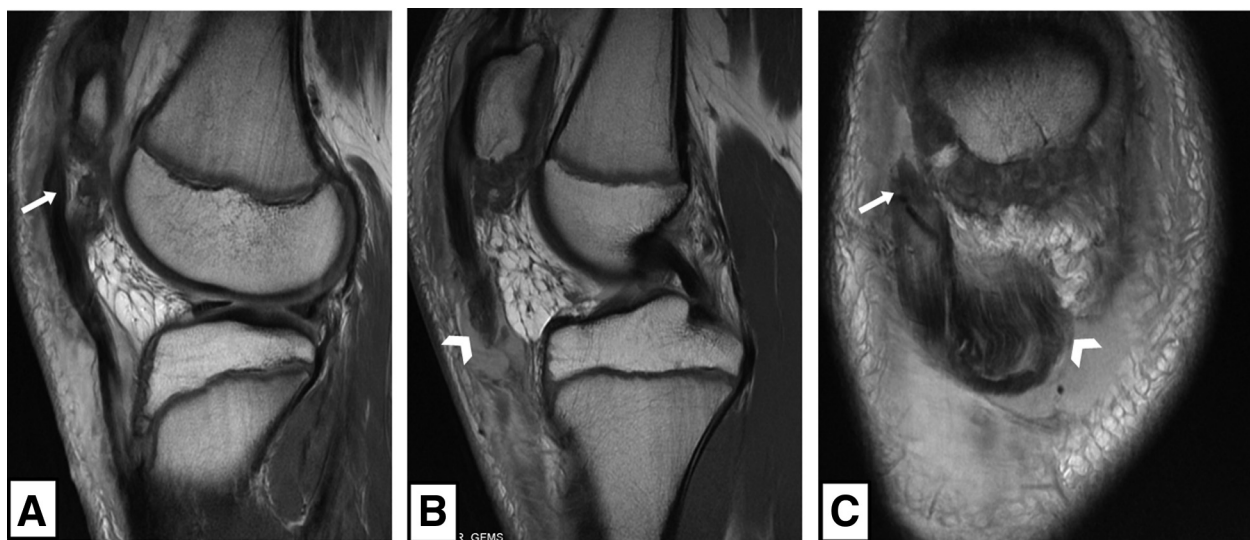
Case 4 preoperative magnetic resonance imaging (MRI) (right knee). Preoperative sagittal proton density MRI sequences from case 4 show proximal avulsion of the inferior patella laterally (A, arrow) and distal avulsion of the patellar tendon medially (B, arrowhead). This can also be seen on the coronal sequence, with lateral avulsion of the inferior pole of the patella (C, arrow) and proximal retraction of the medial patellar tendon due to discontinuity distally (C, arrowhead).
